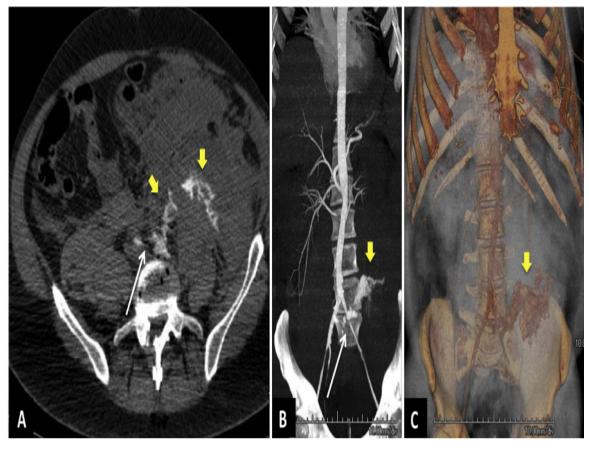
Computed tomographic angiography shows the presence of an arterial leak (yellow arrows), represented by the leakage of the contrast media at the level of the left common iliac artery (white arrow). Panel A: axial view; Panel B: coronal maximum intensity projection view; Panel C: coronal multiplanar reconstruction. In panels A and B images were obtained in an arterial phase, while in Panel C the image was obtained in a venous phase. In Panel C, in comparison with panels A and B an increased amount of contrast can be observed spurring out of the vessel (yellow arrow).
